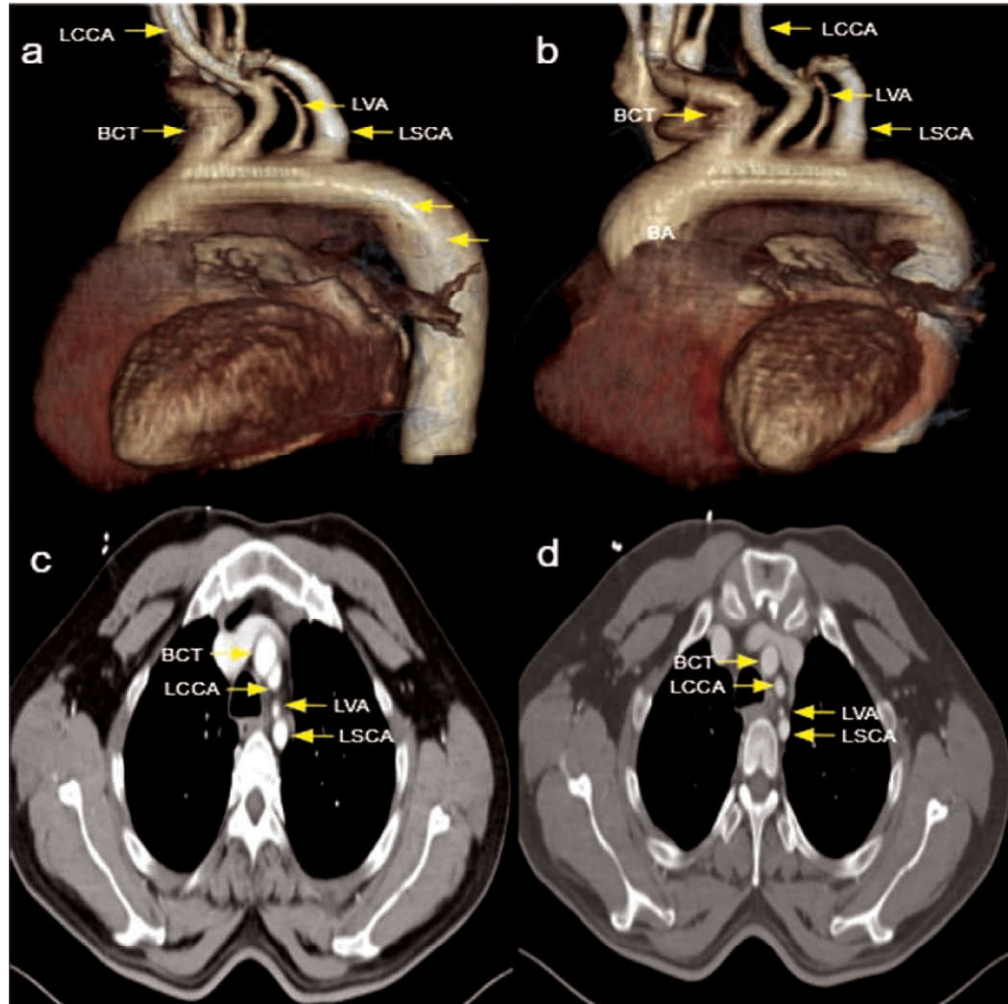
Axial CT chest contrast and VRT images showing the origin of left vertebral artery from aortic arch.
